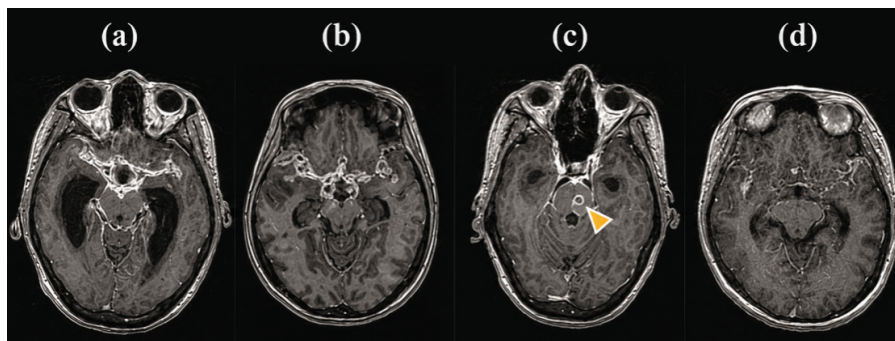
Typical findings on MRI-T1 MPRAGE: (a) basal enhancement, vasculitis with thickened vascular walls, and hydrocephalus with dilated lateral ventricles; (b) basal enhancement; (c) subarachnoid regions (arrow); (d) vasculitis.
